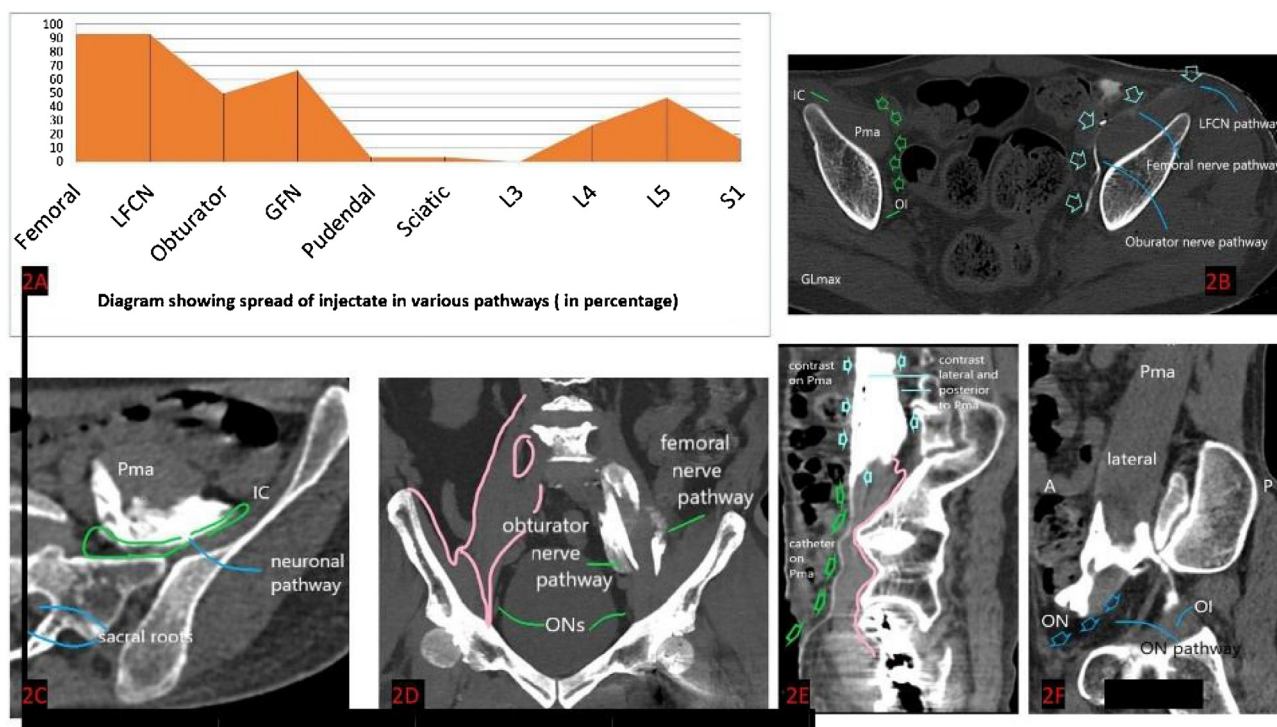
A, CT contrast spread analysis revealing the spread along the femoral, lateral femoral cutaneous nerve (LFCN), Obturator, genitofemoral (GFN), pudendal, sciatic, the L3, L4, L5, and S1 extraforaminal root level; B, Axial view: contrast spread along the anterior surface of Pma, femoral, LFCN, and obturator pathway. It spreads as far as the upper portion of the obturator internus (OI). Pma, psoas major; GL max-gluteus maximus; C, Axial view: contrast spreads in the posterior surface of the Pma and close to the origin of the 5th lumbar nerve root, in the neuronal pathway. Pma, psoas major; IC, Iliacus; D, Contrast spread along the medial and lateral borders of Pma that is along the obturator and femoral pathways. Obturator nerve (ON) can be visualized bilaterally at the pelvic brim; E, Catheter extends from the caudal portion of the Pma until it reaches the level of sacroiliac joint at which point it merges with contrast that spreads cephalad on the anterior border, lateral surface, and posterior border of Pma; F, The anterior and posterior surfaces of the Pma are surrounded by contrast in its lower portion. Contrast trickles from the posterior surface and spills in the obturator (ON) pathway onto the superior surface of obturator internus (OI).
